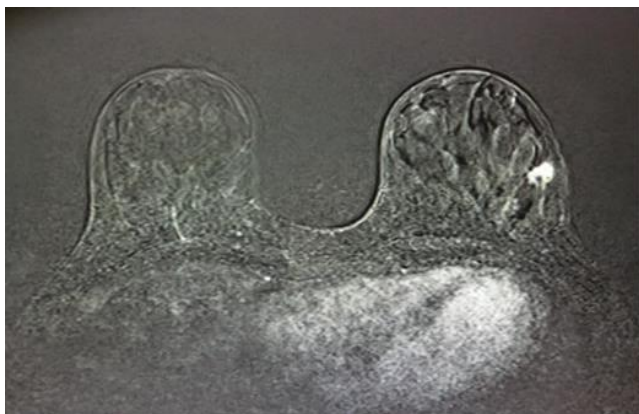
Axial DCE-MRI subtracted image. There is an irregular enhancement in distal 4 o'clock radius of the left breast that was confirmed as carcinoma by biopsy. There are no other pathological images in this or the contralateral breast.
